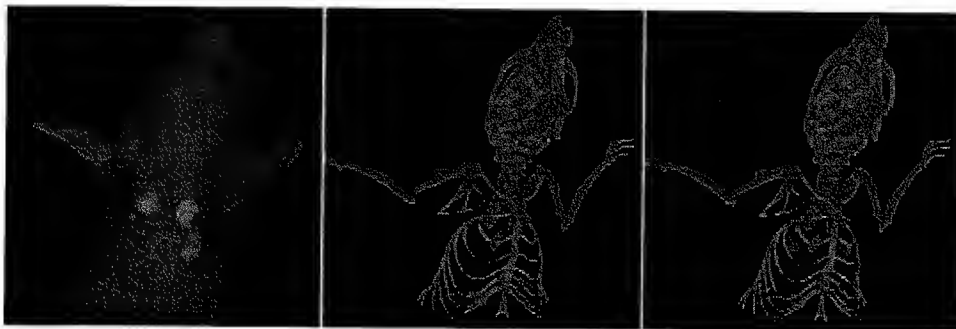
(Right to left) Bioluminescent reconstruction of MDA-MB-231 D3H2 LN-Luc Metastases within the lung. Quantum FX μ CT scan. Co-registration of optical sources and μ CT scan.
